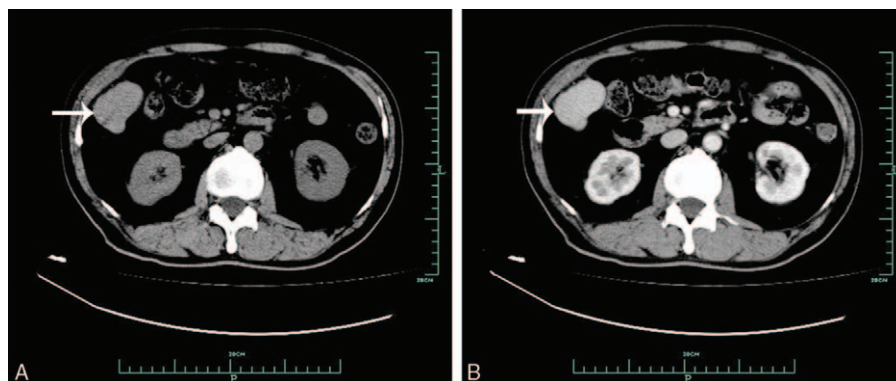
An unenhanced computed tomography (CT) scan showing a well-defined homogeneous mass (arrow) in the area corresponding to the right liver, abdominal wall, and colon, measuring 4.9 × 3.0 cm (A). On the contrast-enhanced CT scan, the mass (arrow) is homogeneously enhanced (B).
